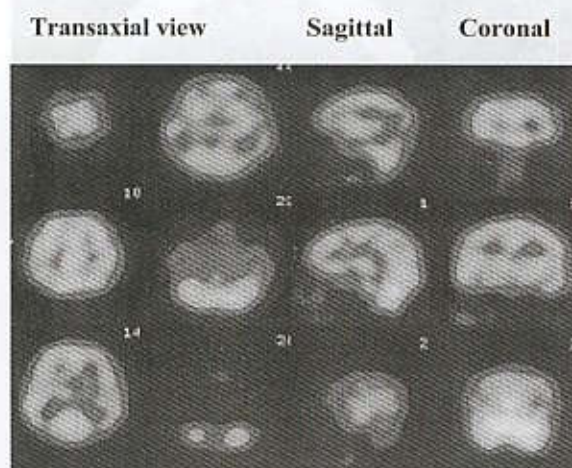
^{99m}Tc -ECD Brain SPECT images of the patient show decreased uptake in the bilateral posterior parieto-temporal regions suggestive of Alzheimer's disease.
